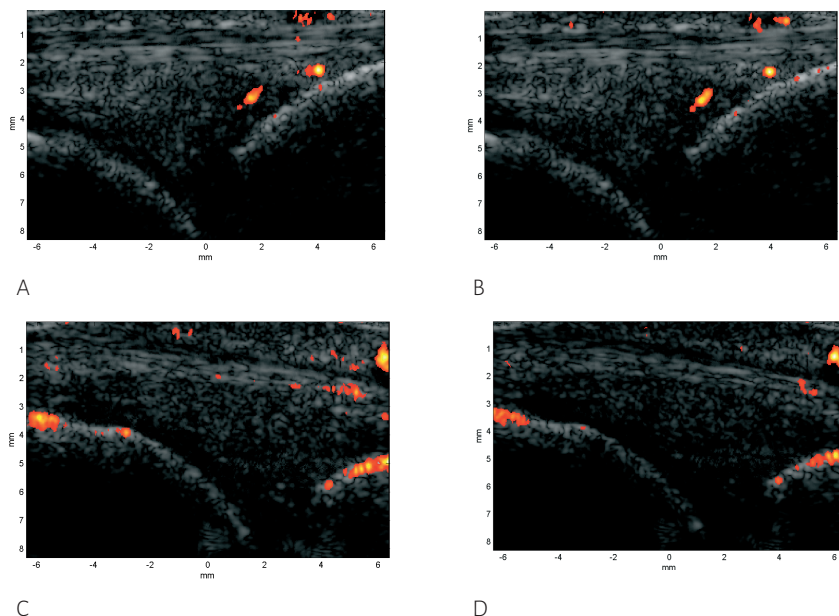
Variability of power Doppler signals when the probe was held in the hydrostatic arm (A, B) and when manually held (C, D).
